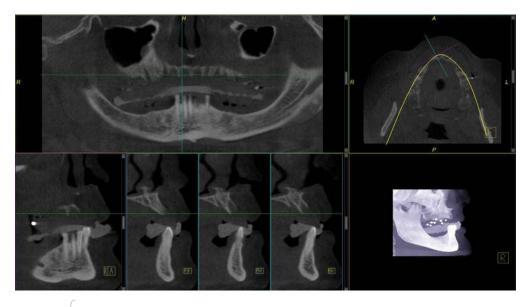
Software for CBCT studies allows not only surgical planning but also prosthetic planning. Note the trajectory of the premaxilla and the thin buccal plate.
